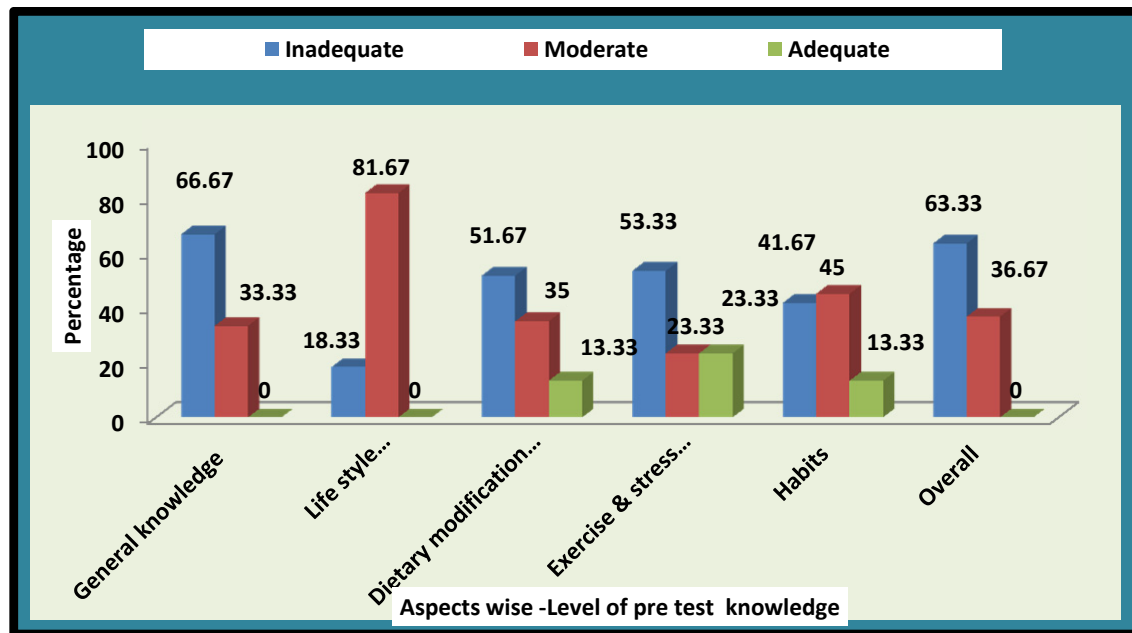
FREQUENCY AND ASPECT WISE PRE INTERVENTIONAL KNOWLEDGE SCORE
